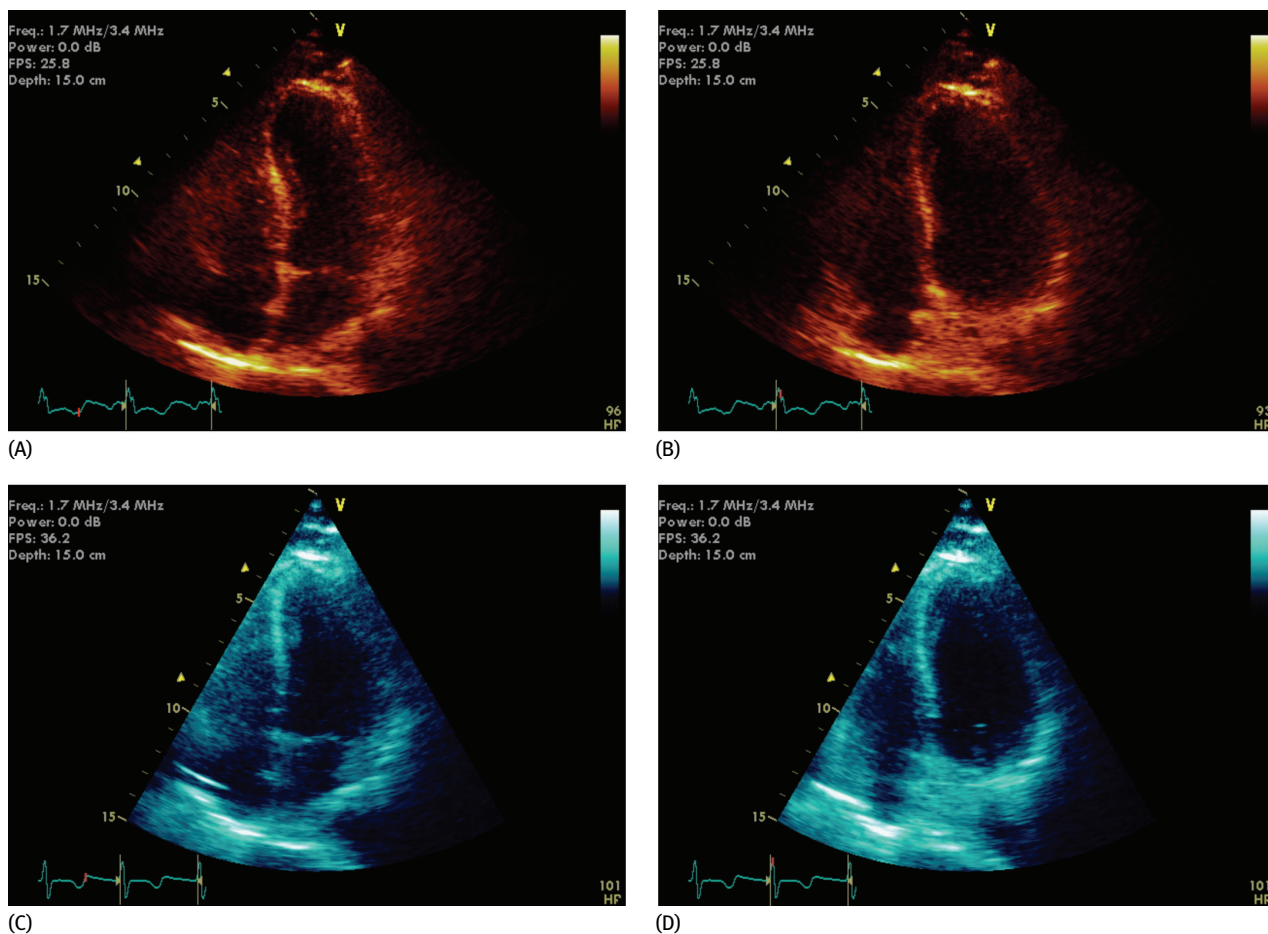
Echocardiography at end-systole (A) and end-diastole (B) 1 day following combretastatin administration. Note the periaipical thinning suggestive of aneurysm formation. Follow-up echocardiography at end-systole (C) and end-diastole (D) performed 3 weeks following initial echocardiogram was remarkable for significantly improved LVEF and periaipical wall-motion abnormality seen earlier.
